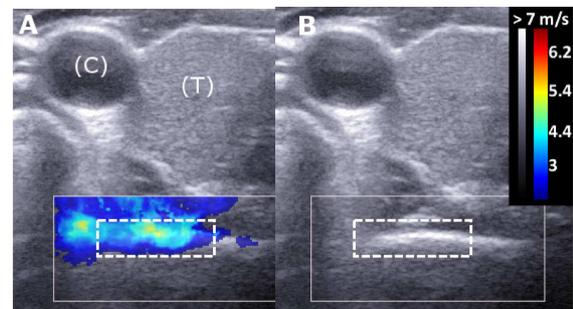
Example of elastographic (A) and ultrasonographic images (B) of IVD annulus fibrosus (dashed rectangle). Colour chart indicates SWS. (C): carotid artery, (T): thyroid.
